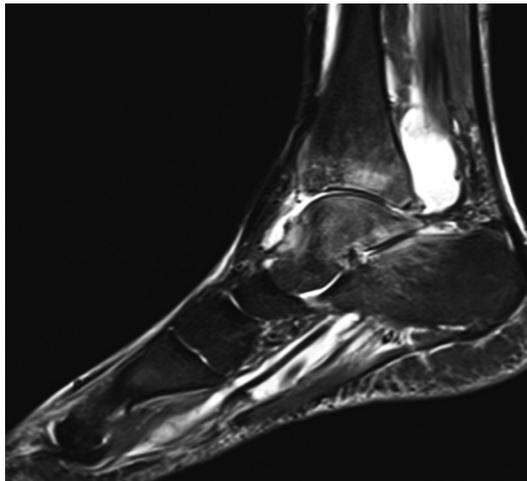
MRI pus collection left ankle joint
